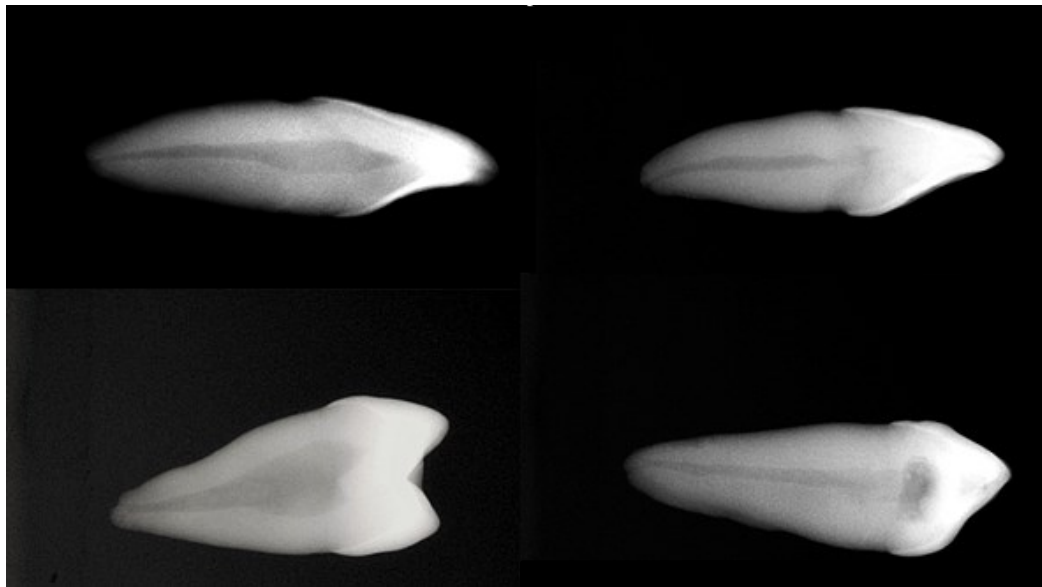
The verification of root canals by means of X-ray.
